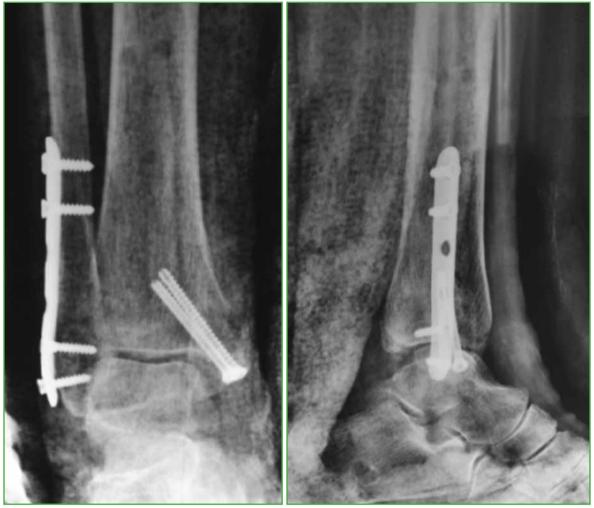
Postoperative X-rays of MIPO of the ankle in a 95-year-old patient.
